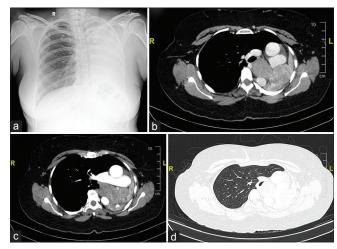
(a) Chest radiograph showing complete left homogeneous opacity with shifting of mediastinum to the same side. (b-d) Computed tomography scan thorax mediastinal (b and c) and lung (d) window showing total collapse of the left lung, enhancing lobulated soft-tissue density in the distal zone of the trachea extending to the left main bronchus
